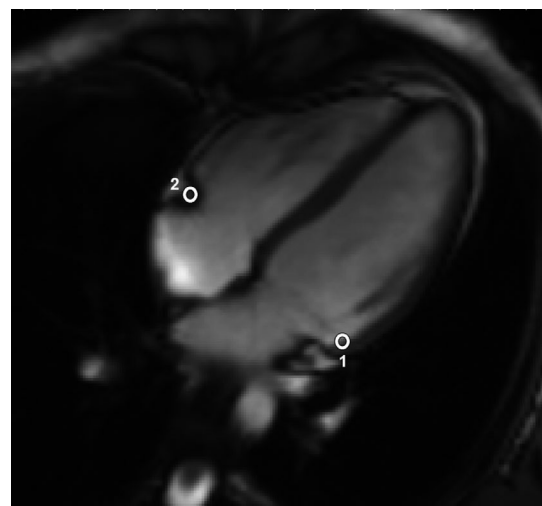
Mitral and tricuspid annular plane systolic excursion reference markers at end-diastole for semi-automatic measurement using cardiac magnetic resonance imaging. The reference markers at end-diastole for MAPSE (1) and TAPSE (2) are denoted
